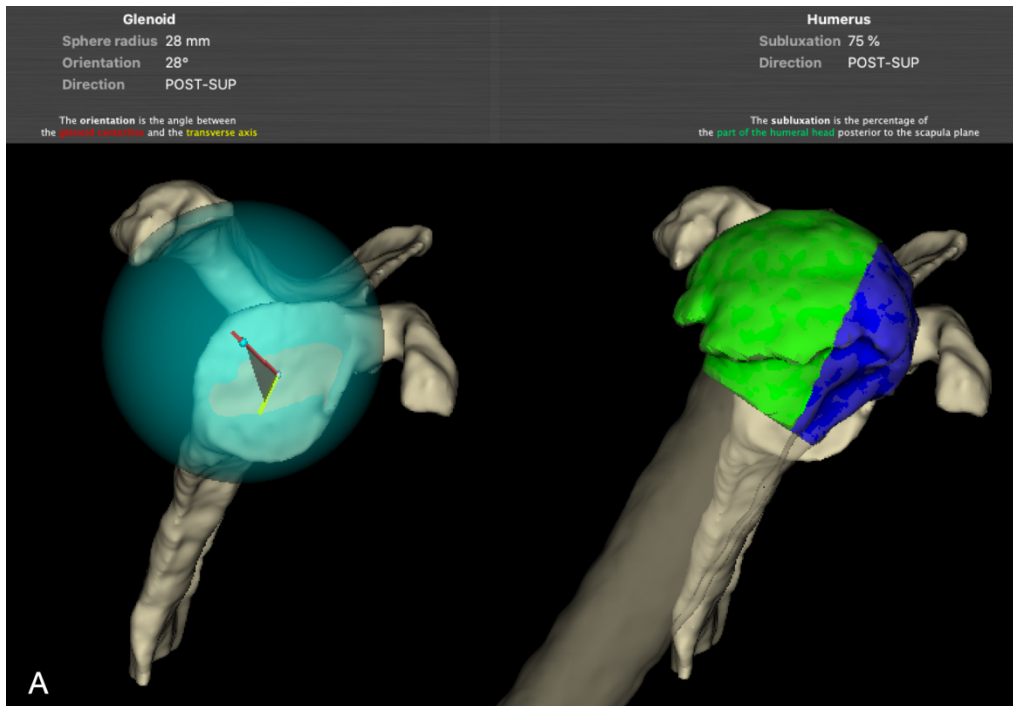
Primary shoulder osteoarthritis with severe glenoid bone loss (B2 glenoid), A) Advanced measures of 3D CT planning representing the orientation (22°) and direction (posterior or posterior-central) of the glenoid wear, and the amount of posterior humeral head subluxation (79%, posterior-superior), B) 2D CT scan with the calculated values of glenoid retroversion and inclination, C)
